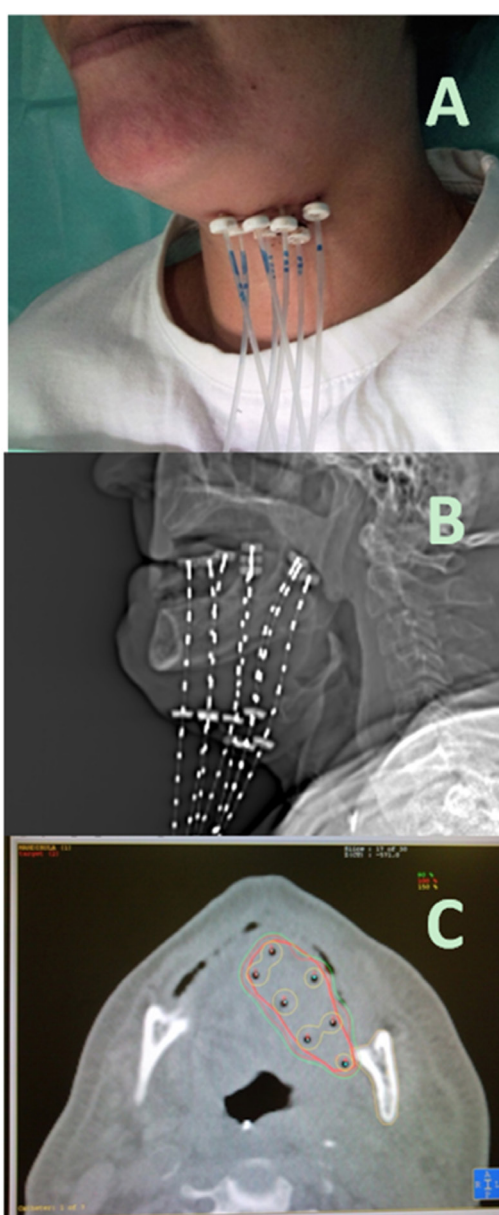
High dose rate brachytherapy for oral tongue carcinoma. (A) showing external outward appearance of percutaneous catheters for afterloading technique; (B) digital radiographic reconstruction of the implant for planning purposes; (C) computed tomography axial view showing high isodose lines covering tumor bed but sparing contralateral tongue, mandible and lips (courtesy of Dr. José Luis Guinot from Instituto Valenciano de Oncología)
